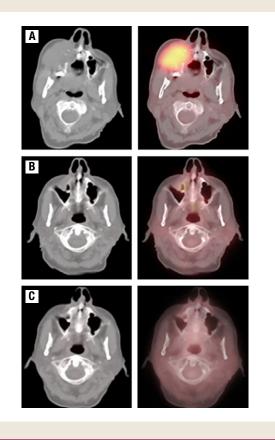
Tumor Imaging. Computed Tomography and Positron Emission Tomography Images (left and right images, respectively) at (A) Diagnosis, (B) 2 Months Later, and (C) 7 Months Later
